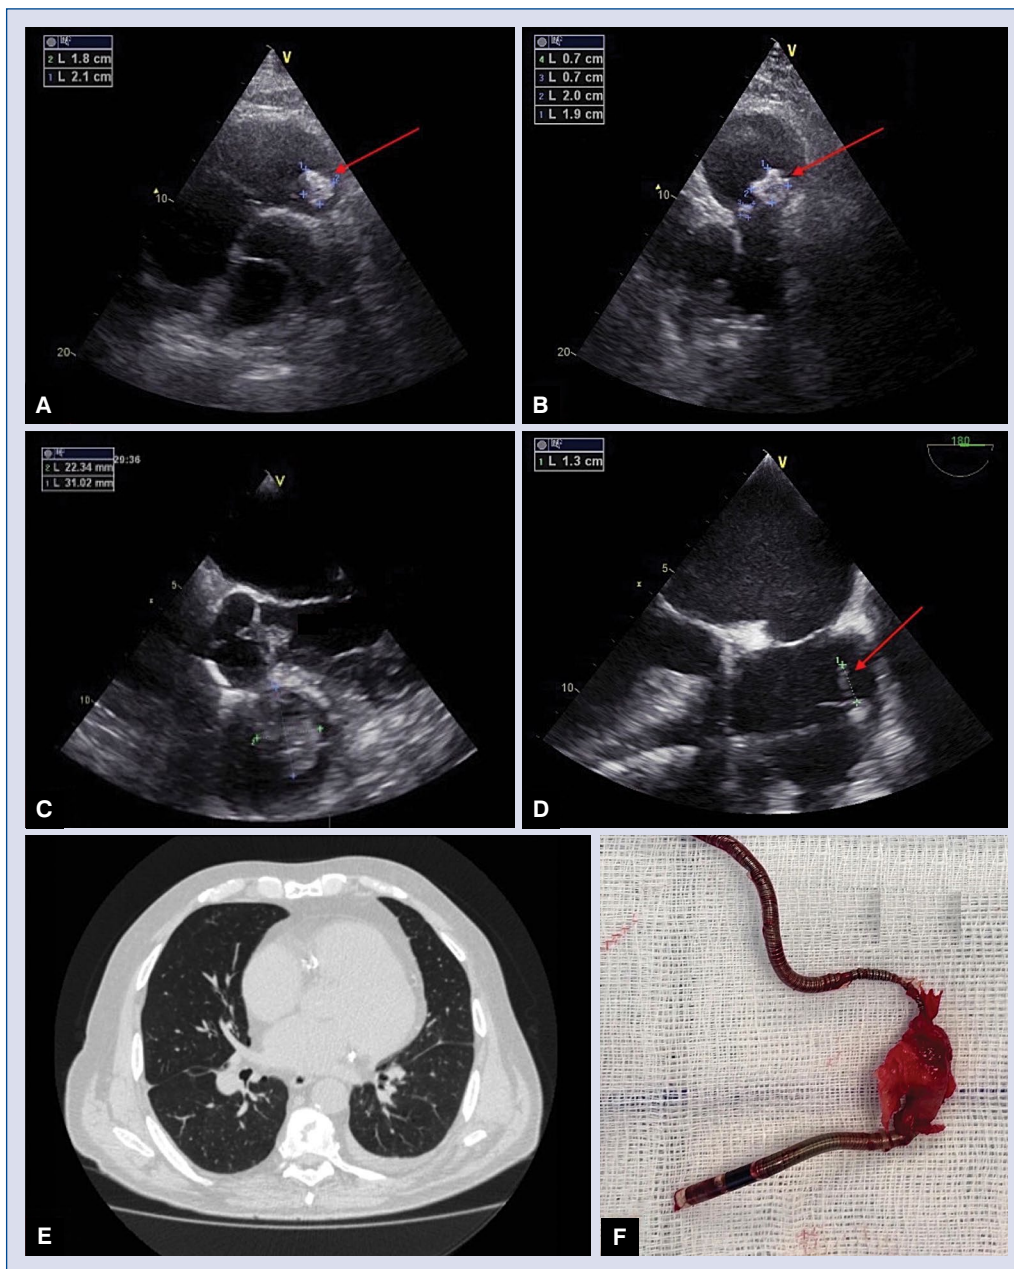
A. Two-dimensional transthoracic echocardiography (2D TTE) parasternal short-axis view at the level of the great vessels: vegetation is visible at the pulmonary artery valve (main pulmonary artery focused projection); B. 2D TTE focused on the pulmonary valve; C. Large vegetation (22 × 31 mm in size) in right ventricular outflow tract seen in transesophageal echocardiography (TEE); D. TEE showing atrial lead vegetation; E. Computed tomography scan showing multiple bilateral lung opacities mimicking malignancy that turned out to be inflammatory; F. Atrial lead vegetation (intraoperative photography).
